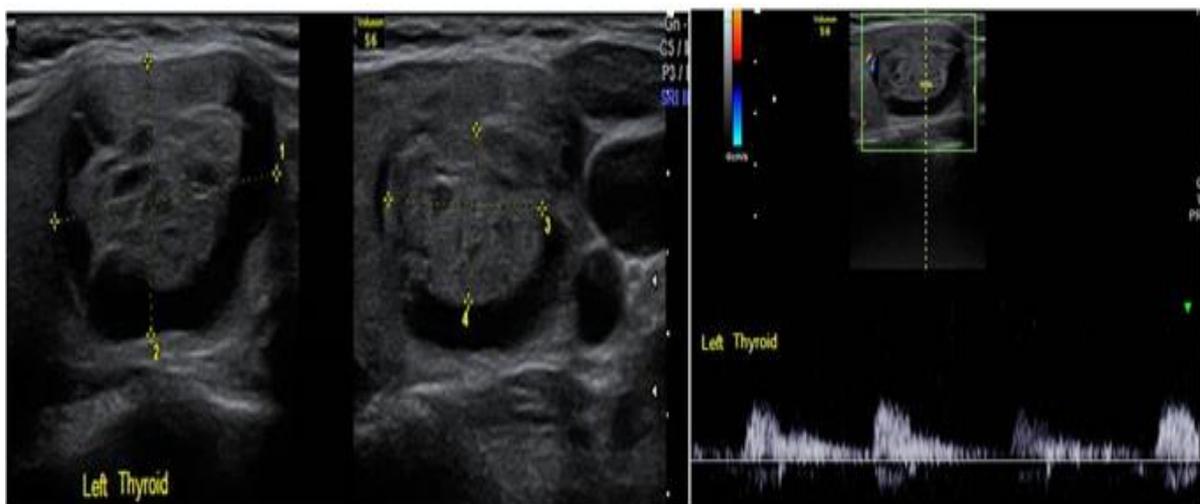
(A-C). 26 years old female with Hyperplastic colloid nodule (TIRADS-2). A. The nodule is round, has regular borders, 70 % solid (18x10mm), isoechoic with peripheral crescentic cystic component measures 26x17mm. C. Colour doppler show blood flow within the solid component.
